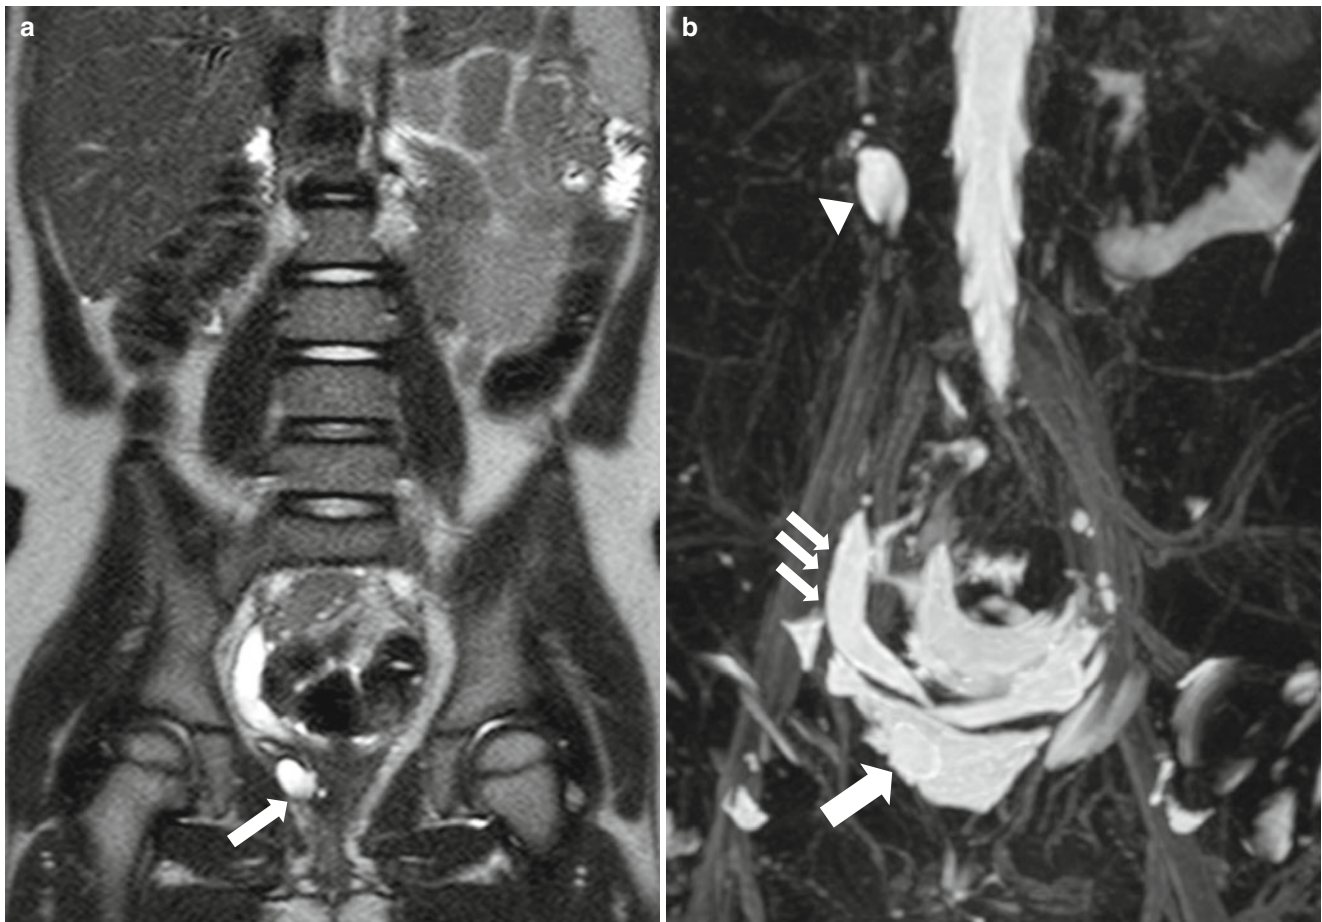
Ectopic dysplastic kidney with ectopic ureterocele in a 5-year-old girl. (a) T2-weighted coronal MR image of abdomen and pelvis shows dilated right distal ureter with ectopic ureterocele (arrow). (b) T2-weighted three-dimensional MR urography demonstrates
